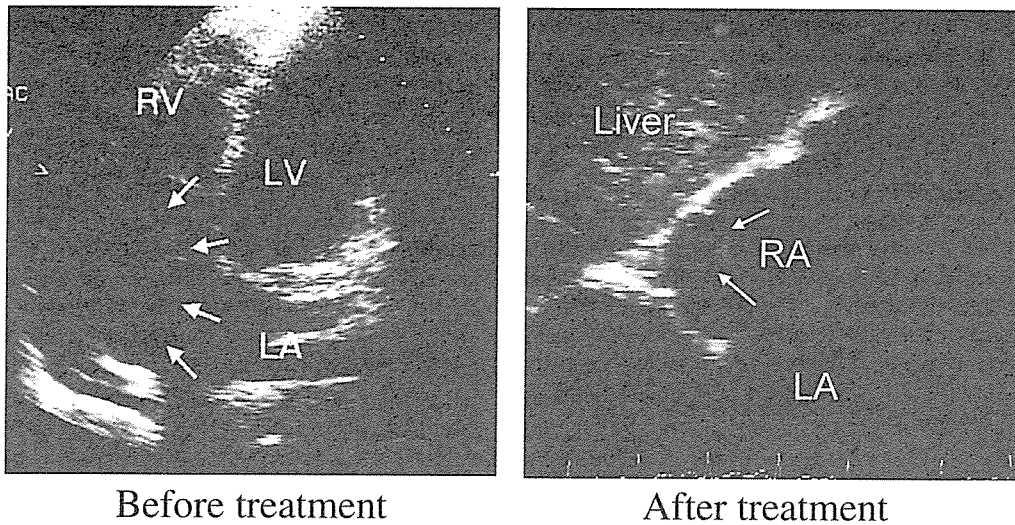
Echocardiography before (Left) and after chemotherapy (Right). Before treatment, the apical 4-chamber view shows a huge mass in the right atrium (arrows). After treatment, the subcostal view shows shrinkage of the mass (arrows). LA, left atrium; LV, left ventricle; RA, right atrium.
